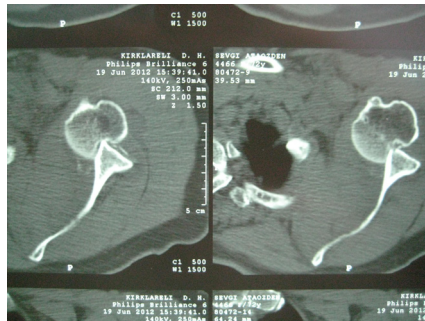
CT shows left shoulder dislocation
